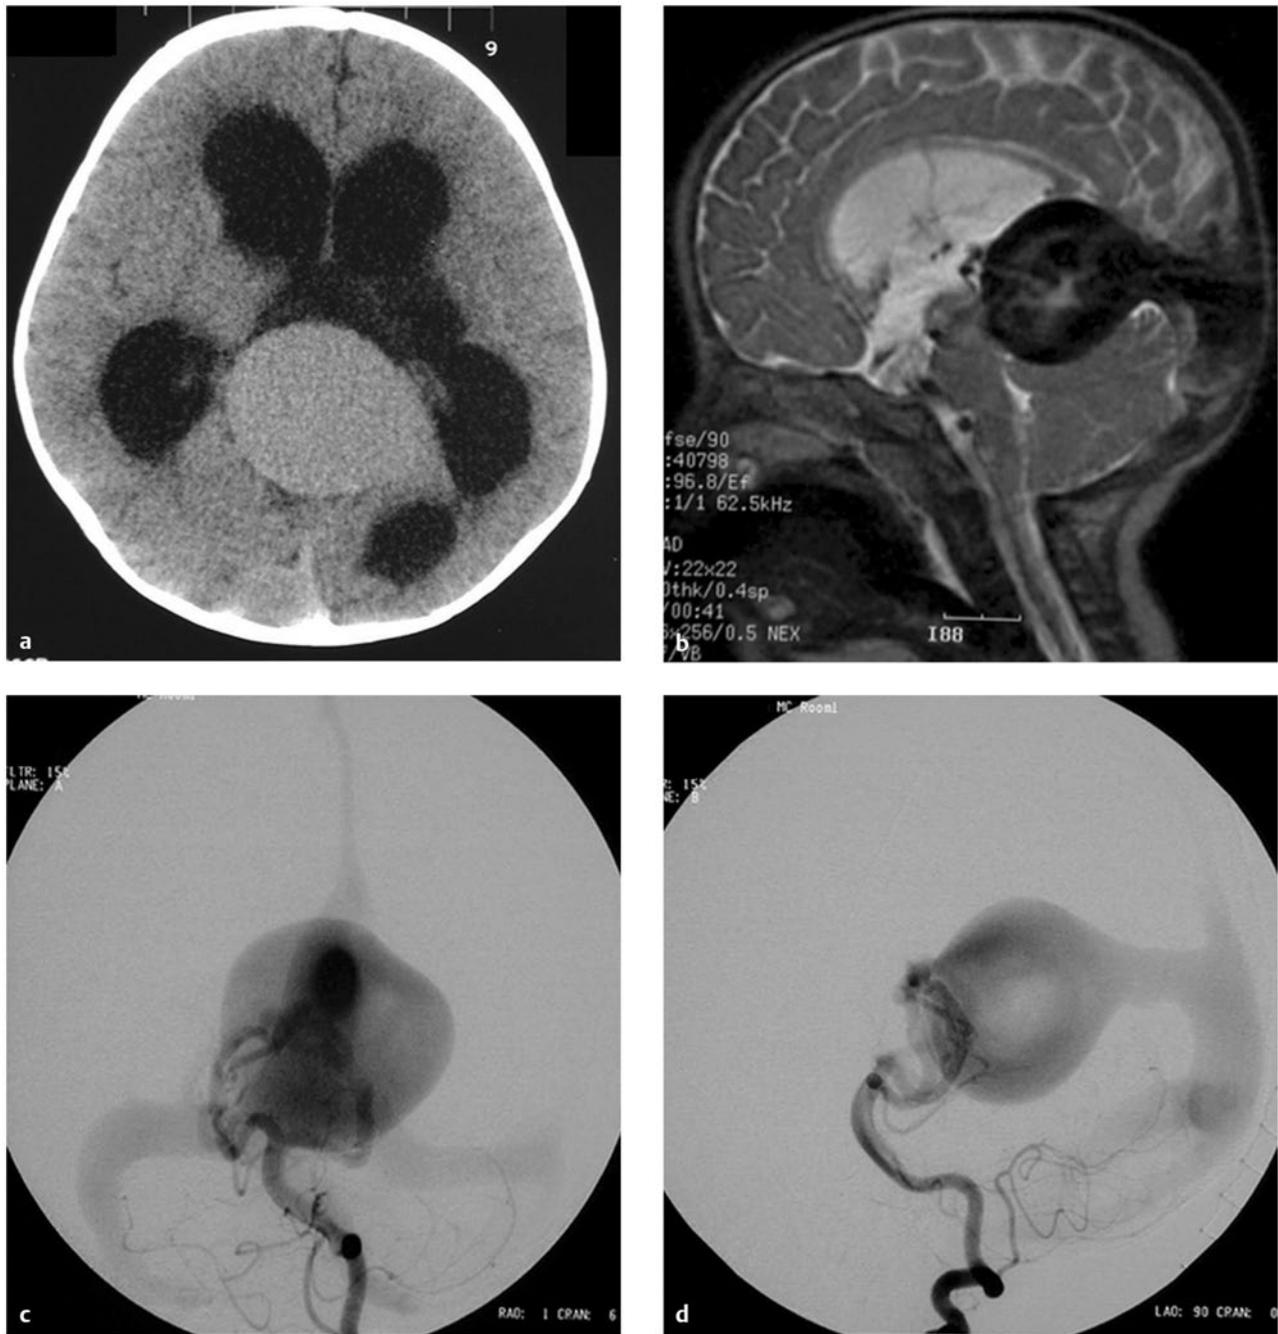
A 6-month-old female patient presented with macrocephaly. The patient was developing normally. (a) Computed tomographic scan without contrast demonstrates hydrocephalus and a large midline vascular structure. (b) T2-weighted sagittal magnetic resonance (MR) image demonstrates a large midline vein draining to the embryonic falx and hydrocephalus. Left vertebral artery in the (c) anteroposterior (AP) and (d) lateral views demonstrates a mural-type vein of Galen aneurysmal malformation (VGAM) supplied by bilateral posterior choroidal arteries. The dilated median vein of the prosencephalon is draining to the embryonic falx with reflux to the superior sagittal sinus. (*continued*)
